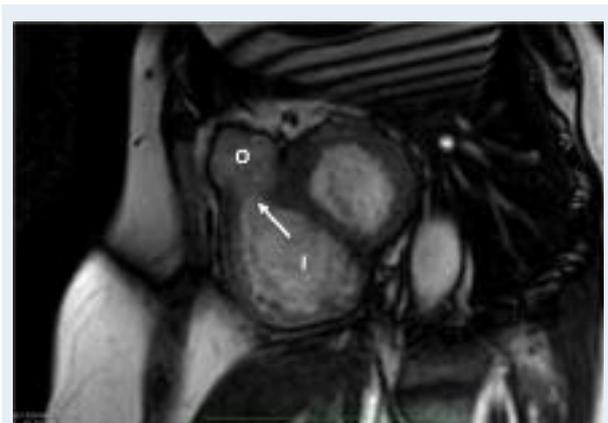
Sagittal T2-weighted cardiac magnetic resonance image shows localized right midventricular obstruction (white arrow) dividing the right ventricle into two chambers, inlet (I) and outlet (O).
